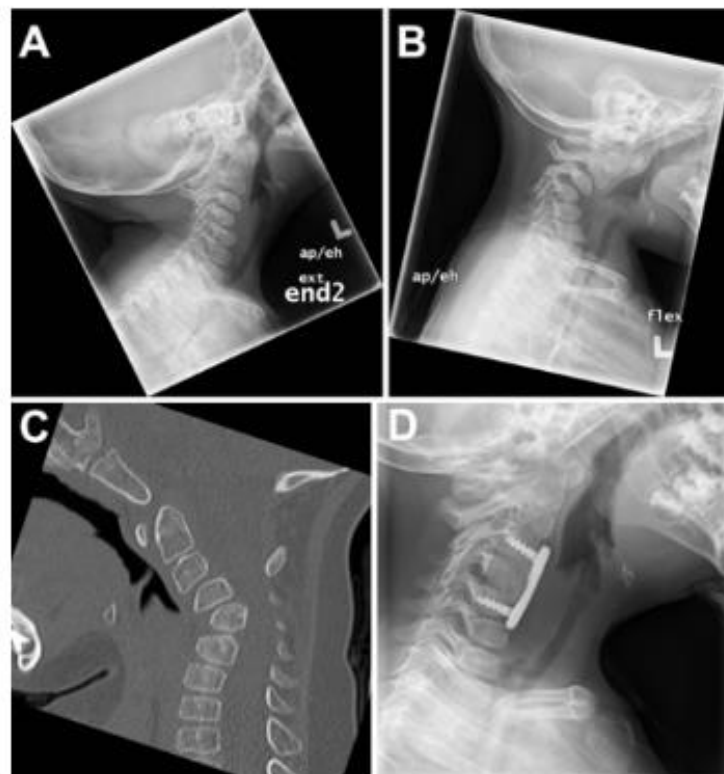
Case 1. Extension (A) and flexion (B) radiographs of the cervical spine showing anterior subluxation of C-3 onto C-4. Sagittal noncontrast CT scan (C) of the cervical spine shows a hypoplastic C-4 vertebral body. Postoperative lateral cervical spine radiograph (D) obtained at 17-month follow-up showing bony fusion around the plate and no evidence of subsidence or hardware failure.
